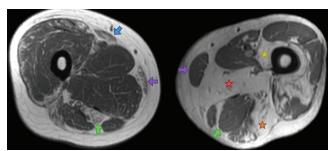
Thigh muscle findings in myofibrillar myopathies. In desminopathies (left), MRI findings show preferential involvement of the semitendinosus (green arrow), sartorius (blue arrow), and gracilis (purple arrow), with sparing of the adductors and other posterior thigh muscles. In contrast, in myotilinopathies (right) and filaminopathies, the biceps femoris (orange star), adductor magnus (red star), semimembranosus (blue star), and vastus medialis (yellow star) are most affected, and the semitendinosus (green arrow), and gracilis (purple arrow) are spared.
